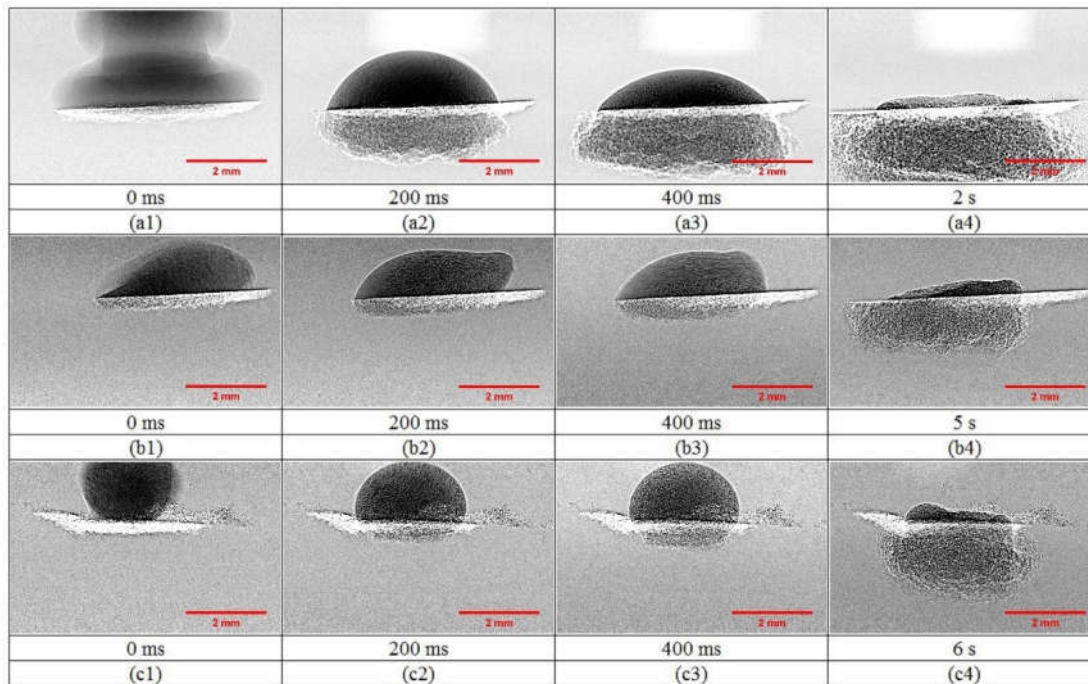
Time sequence X-ray images of the granulation process for LMH powder with (a1-a4) water; (b1-b4) isopropanol; and (c1-c4) ethanol, as a liquid binder with a drop height of 2.5 cm and a droplet volume of 15 μl .
